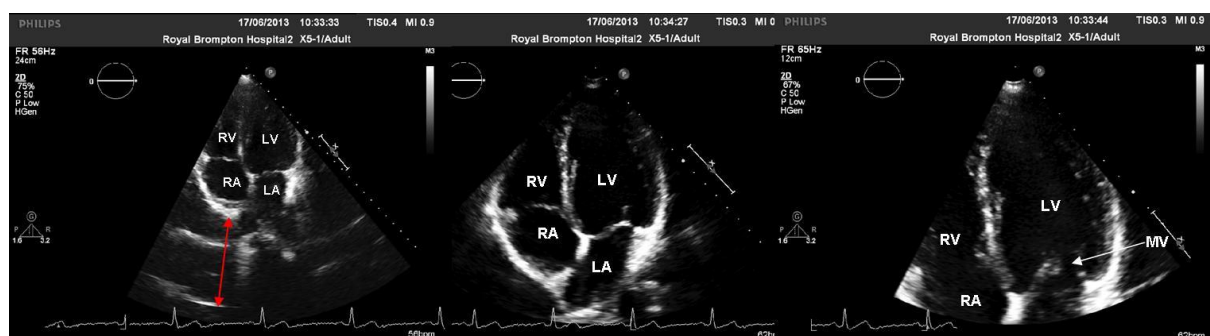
Apical 4-chamber views showing the effect of altering the depth setting on the ultrasound machine. In the central image the depth setting is optimal to view all four cardiac chambers at 20cm. In the image to the left the depth setting has been increased excessively (28cm) and there is a large amount of “wasted” space in the sector (indicated by the red arrow). This will reduce the image quality. In the image to the right the depth setting has been reduced excessively (12cm) and the atria are only partially visible (for full explanation see text).
